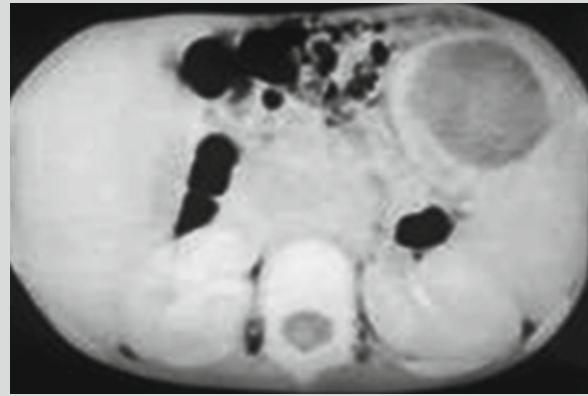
Leptospirosis with hepatic and splenic lesions. CT scanning demonstrates the swelling of spleen, with a size of 6 cm × 4 cm
